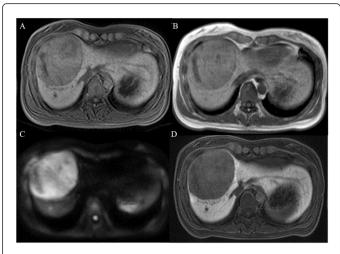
(A) T1 weighted image (B) T2 weighted image (C) EOB-MRI image (D) diffusion weighted image. These images showed liver tumor in segment 4, which was 91 mm in size, hypointense on EOB-MRI and highintense on diffusion weighted image.
